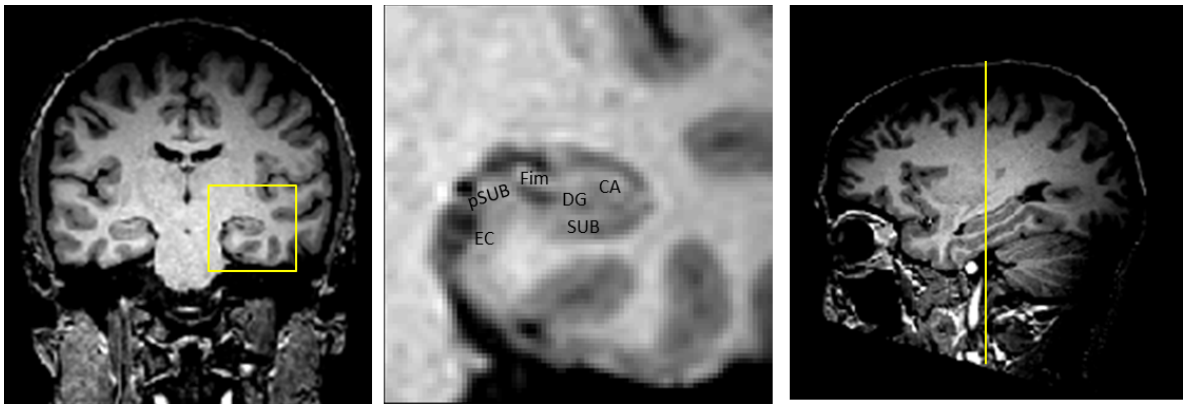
Subfields of the hippocampal complex. CA= Cornu Ammonis , DG = dentate gyrus , SUB= subiculum, Fim=fimbria, EC = entorhinal cortex, pSUB=parasubiculum. Structural MR image from an adult male tested in Experiment 7.
